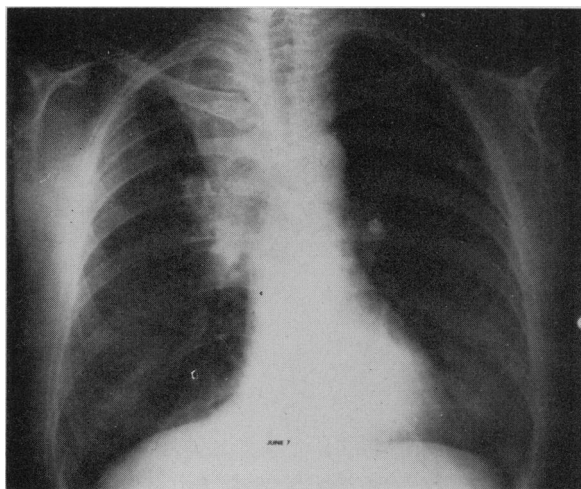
Chest radiograph taken on admission. The upper segment tumour shadow is clearly seen on the right.
